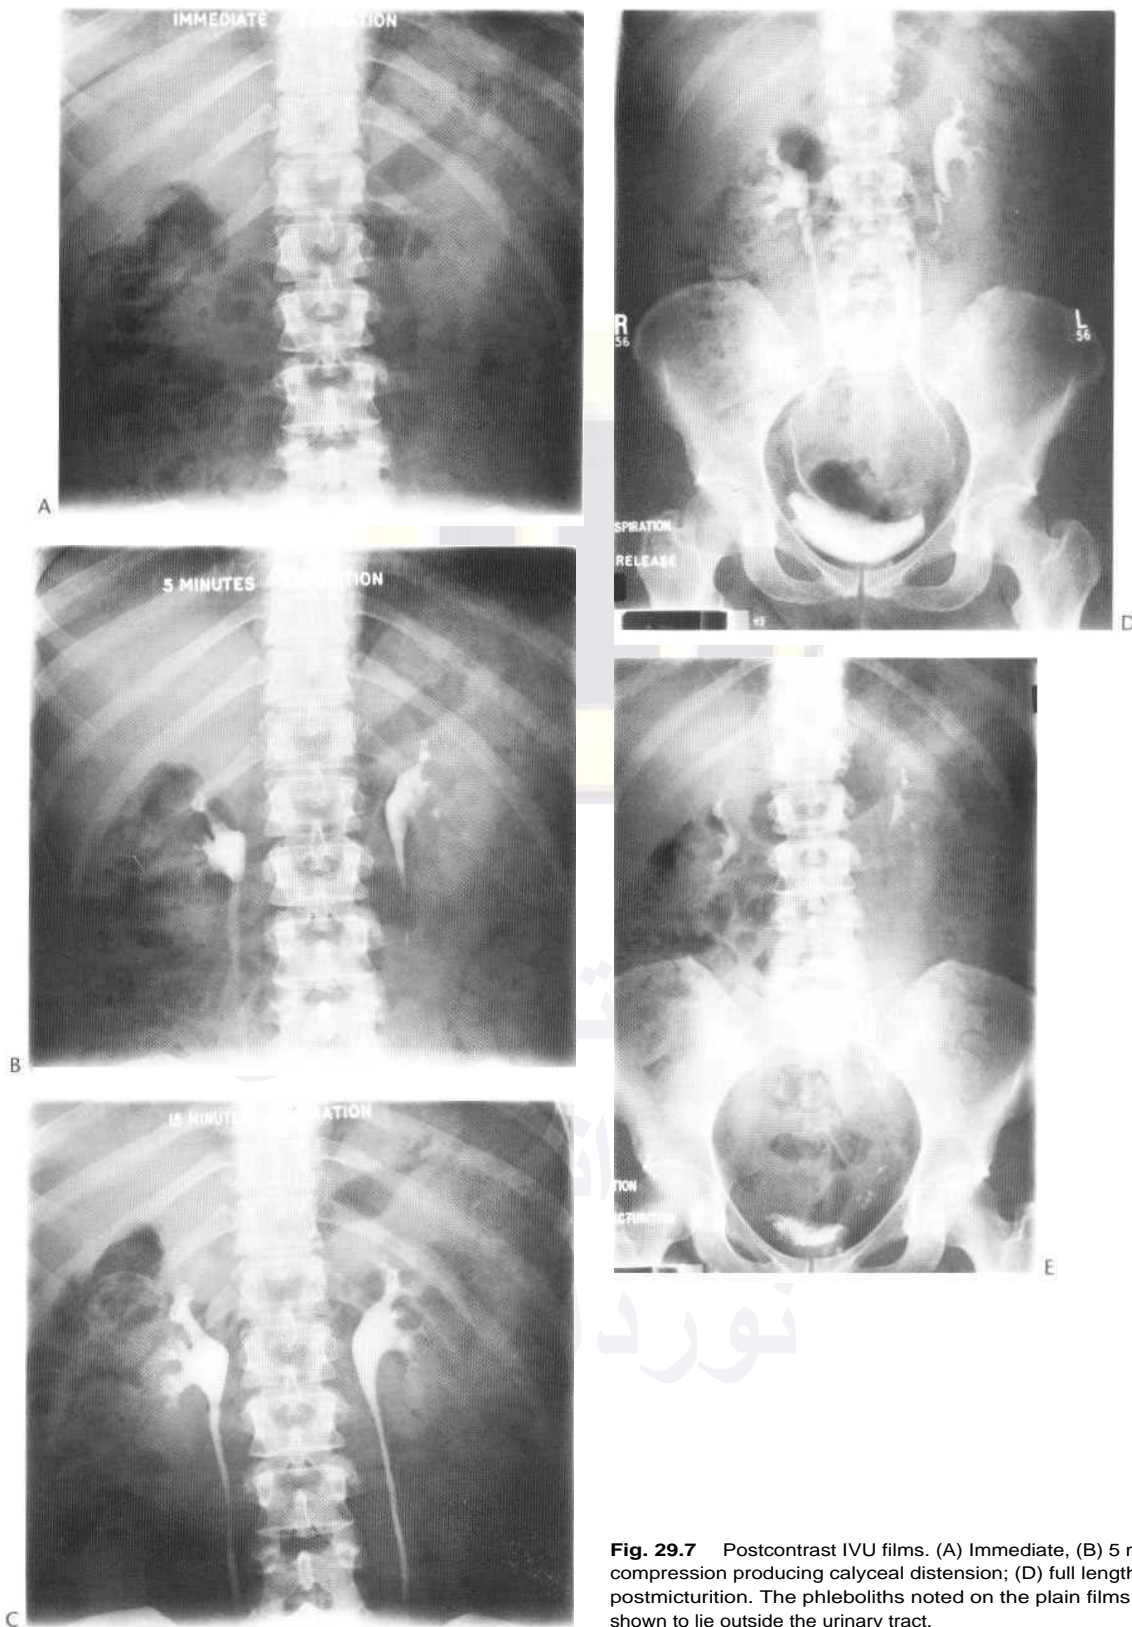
Postcontrast IVU films. (A) Immediate, (B) 5 min, (C) 15 min film with compression producing calyceal distension; (D) full length release; (E) full length postmicturition. The phleboliths noted on the plain films (Fig. 29.6A) are nicely shown to lie outside the urinary tract.
